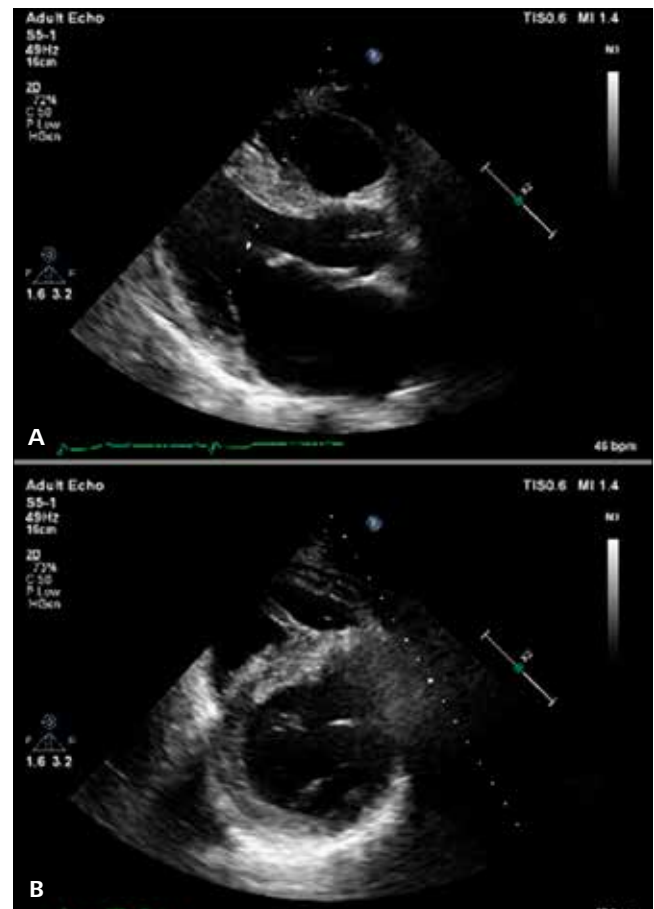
Transthoracic echocardiographic study showing interventricular septum hypertrophy consistent with hypertrophic cardiomyopathy. A. Parasternal long axis view. B. Parasternal short axis view at mitral valve level
